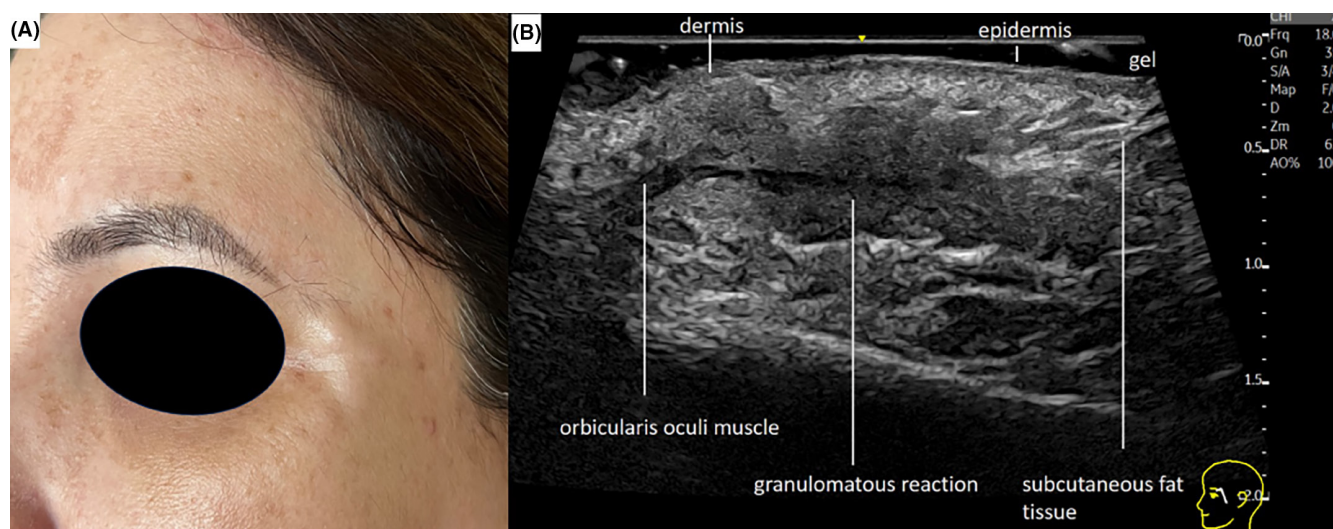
(A) Nodules of polycaprolactone (PCL–Ellansé®) at the medial limit of the temporal region. (B) High-frequency grayscale ultrasound (18MHz), longitudinal incidence, demonstrates poorly defined hypoechoic granulomatous tissue where polycaprolactone was injected.
